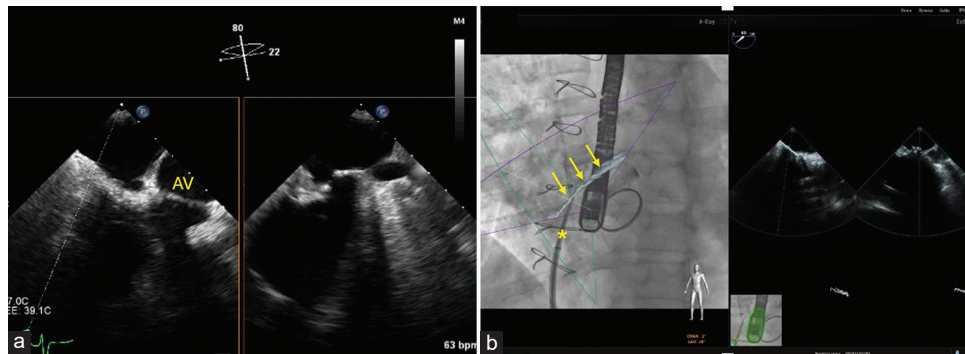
Transseptal puncture in a case of thick postcardiotomy septum: In simultaneous biplane view the sheath BRK assembly approaching IAS is not visible at all on the right side (a). (b) Fusion imaging technology could overcome this limit by the simultaneous combination of echocardiographic image of IAS (arrows) and fluoroscopic image of the sheath BRK apparatus (asterisk)
